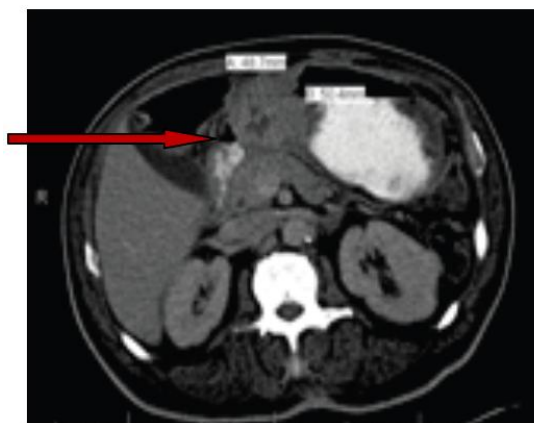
CT abdomen showing 5.0 cm by 4.9 cm soft tissue mass surrounding the pylorus of the stomach
